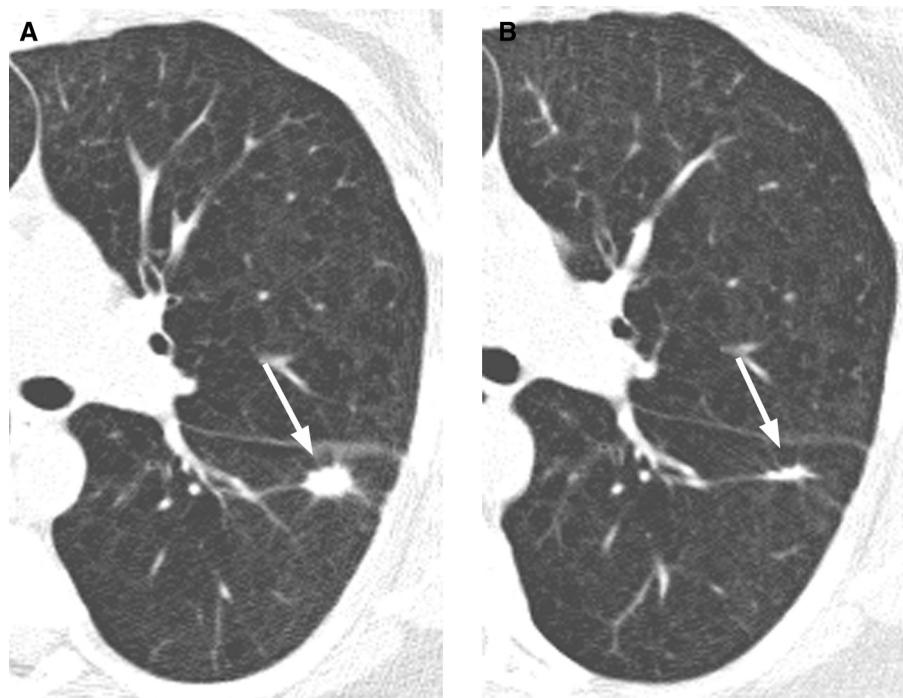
Transient spiculated nodule in a patient with a recent history of pneumonia. (A) Baseline computed tomography (CT) in a patient who was asymptomatic, demonstrating a solid spiculated 15×10 -mm nodule in the left lower lobe (arrow). The patient was found to have had consolidation in the left lower lobe on a chest radiograph obtained for cough and fever 3 months before the baseline CT, and, therefore, the nodule was classified as Lung Reporting and Data System (LU-RADS) 3L (indeterminate; requires serial CT). (B) Follow-up 6 weeks later, demonstrating marked size decrease (arrow). Classification is now LU-RADS 2.
